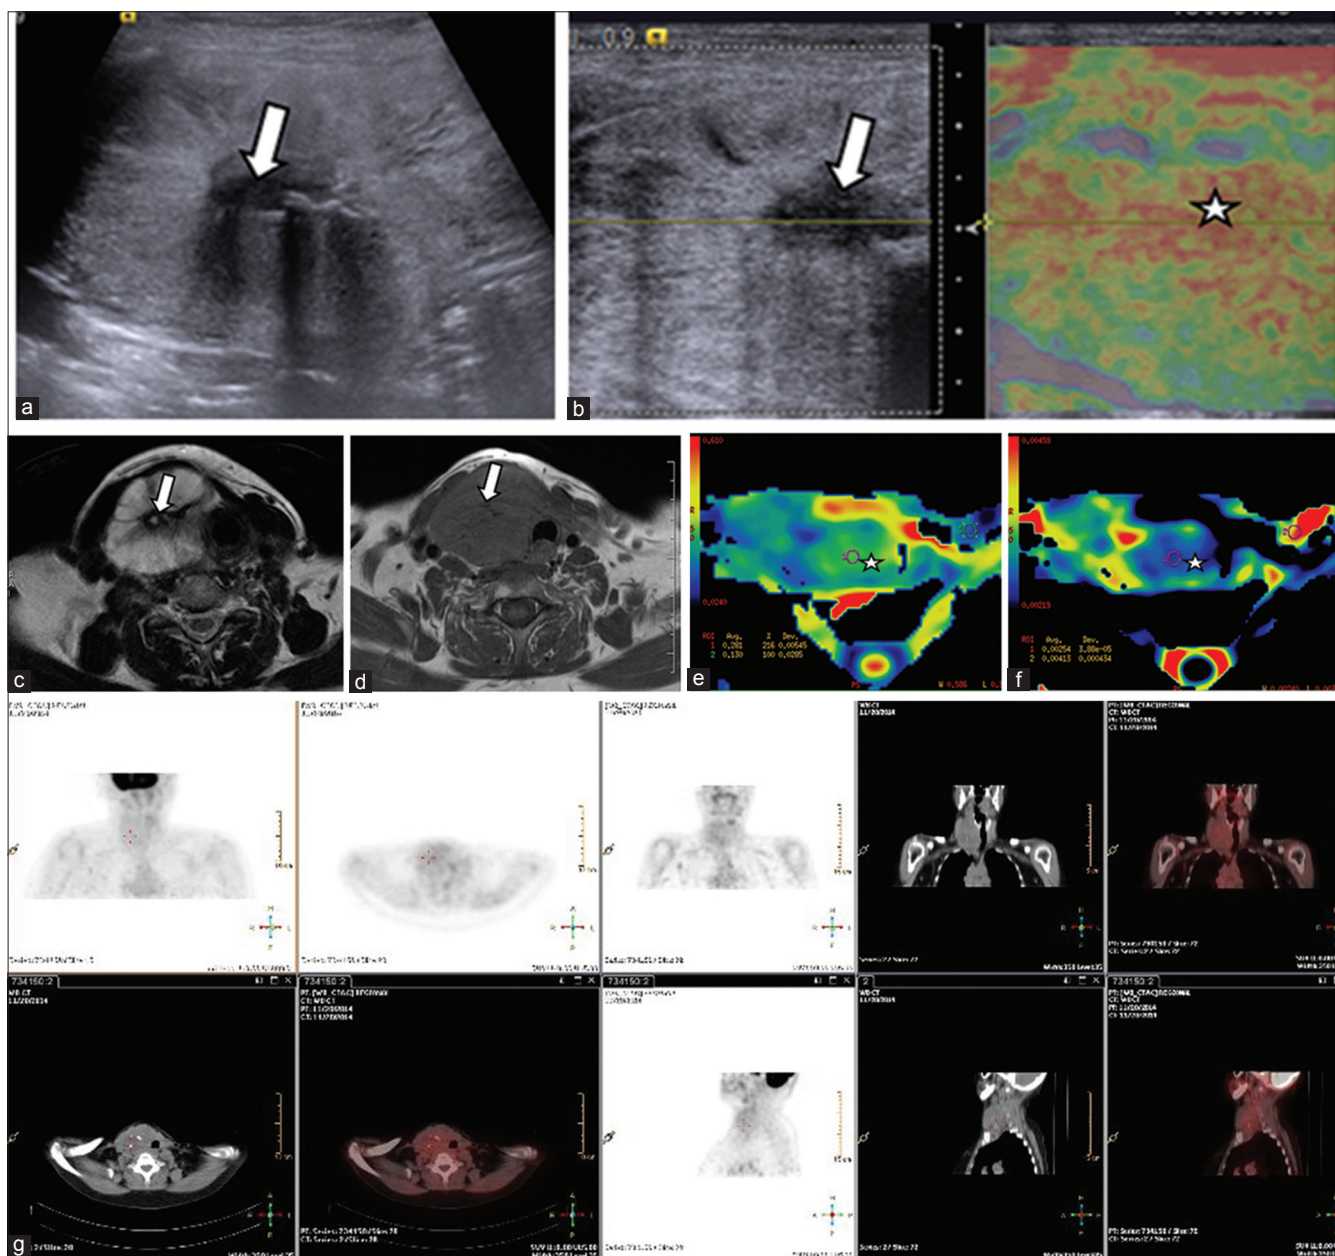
(a) Grey scale ultrasonography demonstrating mixed echogenicity predominantly hyperechoic lesion (6.1 × 3.9 cm) with central macrocalcification (b) Split-screen B-mode ultrasound image (left) and US elastogram (right) showing a focal stiff nodule (star) with predominantly maintained elasticity. The Rago and Asteria Strain elastographic scores of the lesion were 3 and 2 (c and d). Plain axial MRI images showing heterogeneous signal intensity on T2W and predominantly hypointensity on T1W images respectively. Also noted was central darkly hypointense area on both T2W and T1W images representing calcification (arrow) (e and f). Diffusion colored maps of EADC and ADC value obtained from ADC map with b factor 0 and 500. The ADC map shows low values of in the area of stiffness on elastogram (star) corresponds to restricted diffusion with a measured ADC value of $0.34 \times 10^{-3} \text{ mm}^2/\text{s}$. (g) FDG-PET/CT demonstrating very low grade FDG uptake in the nodule
